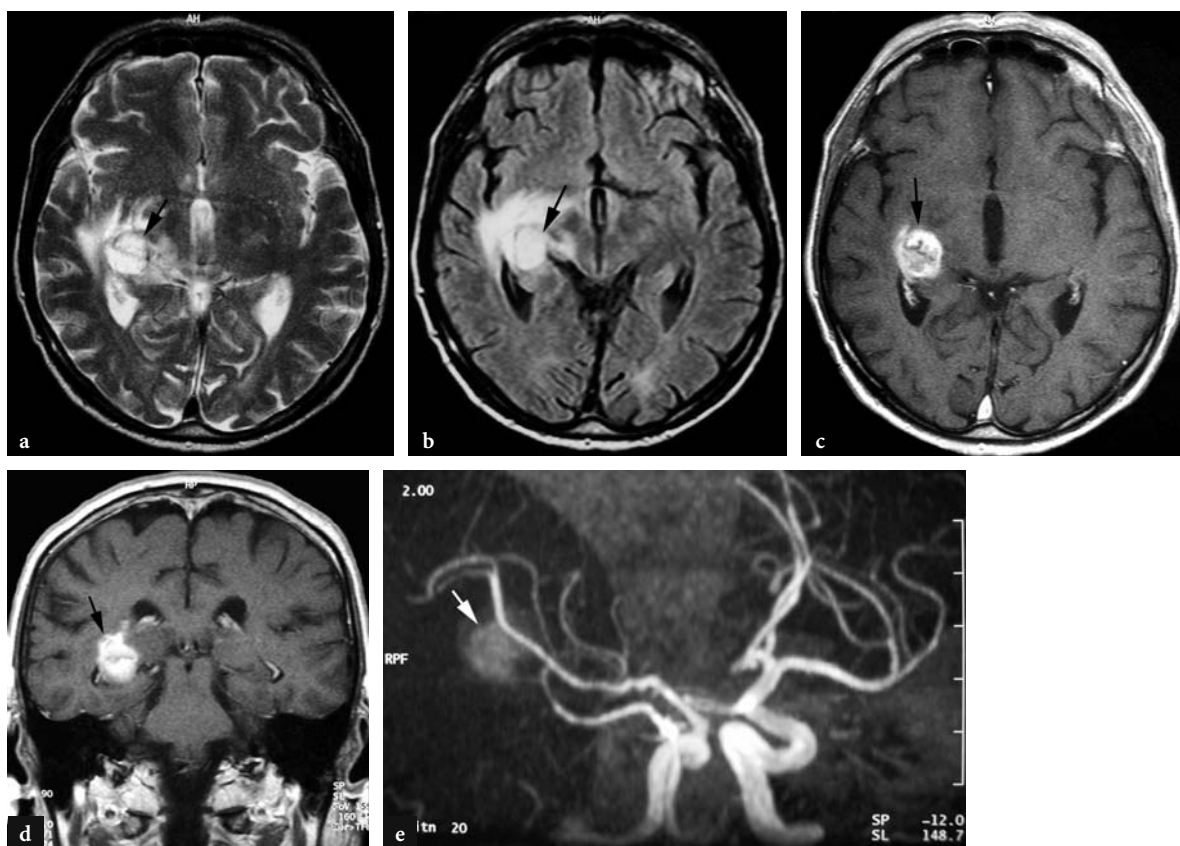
Brain metastases in a 72-year-old man who underwent nephrectomy for renal cell carcinoma. Axial a T2-weighted and b FLAIR MR images show a hyperintense round lesion within the right trigone (*arrow*) and surrounded by a vasogenic edema. c Axial and d coronal contrast-enhanced T1-weighted MR images demonstrate a heterogeneously enhancing mass of the choroid plexus of the trigone (*arrow*). e Cerebral MR angiogram reveals tumor blush in region of the right trigone (*arrow*).
